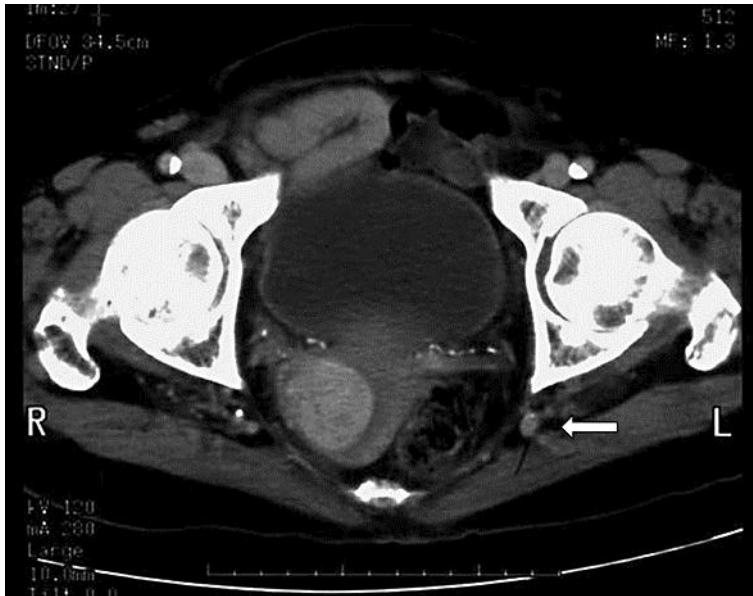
Axial CT scan of the pelvis showing marked hydroureter on the level of the sciatic notch and the passage of the left ureter through the greater sciatic foramen posterior to the ischium, consistent with sciatic ureter.
